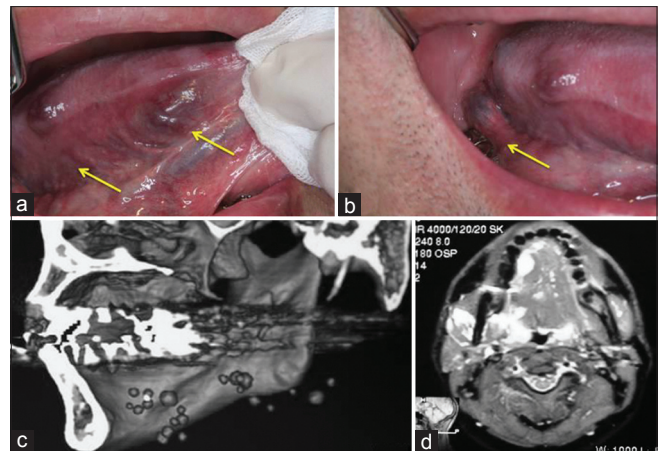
Hemangiomas on right border (a), lower surface and root of the tongue (b). CT showing a mass with multiple phleboliths (c). Contrast enhanced T1-weighted MR imaging shows strongly enhancing mass with smooth borders (d)
